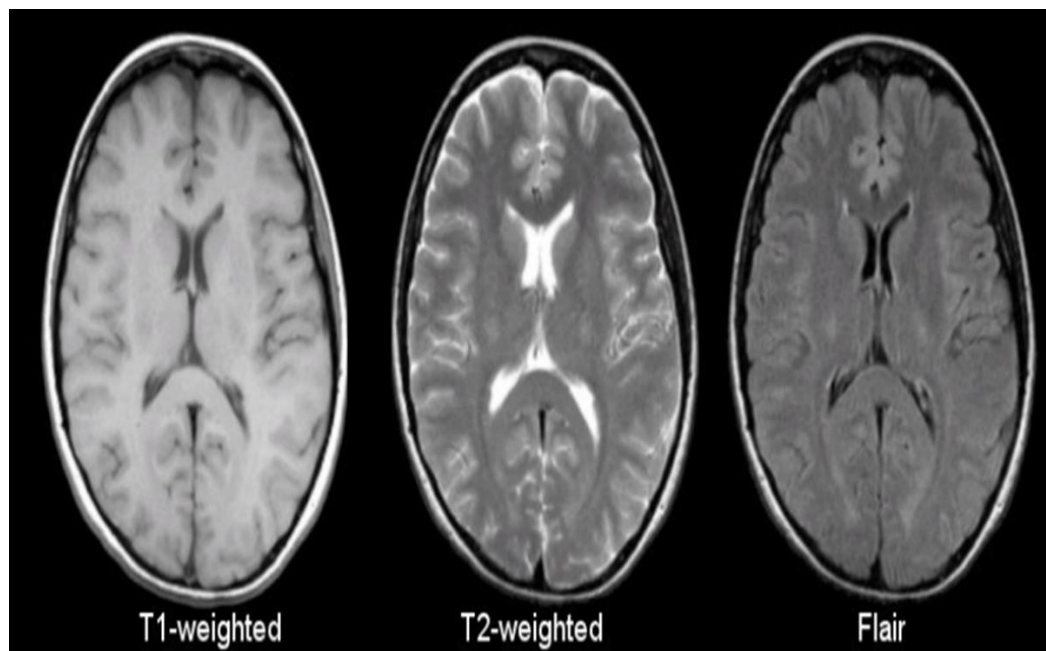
Type of MRI imaging technique
